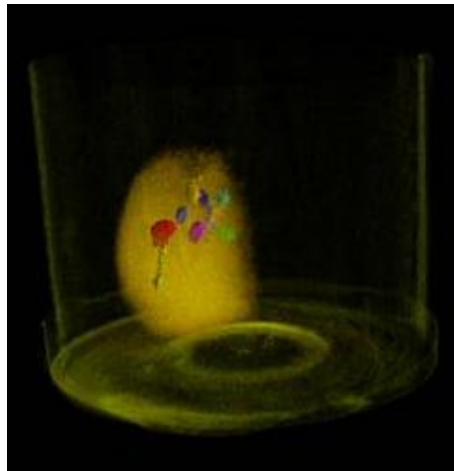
CT 3D image of kidney C with VOIs (volumes of interest). The image shows only the vowels with high attenuation from a certain value of CT
